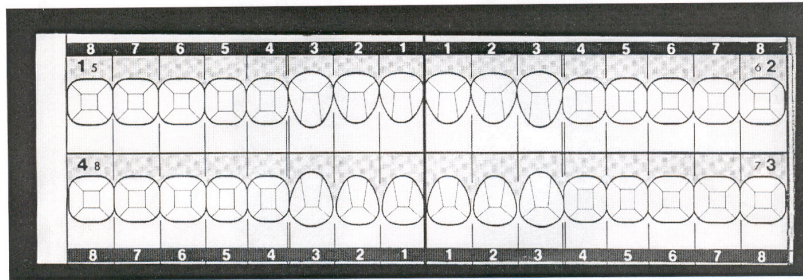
Clinical and radiographic recordings of occlusal and approximal caries grade 1 to 5 (with permission from Espelid, 2017).
